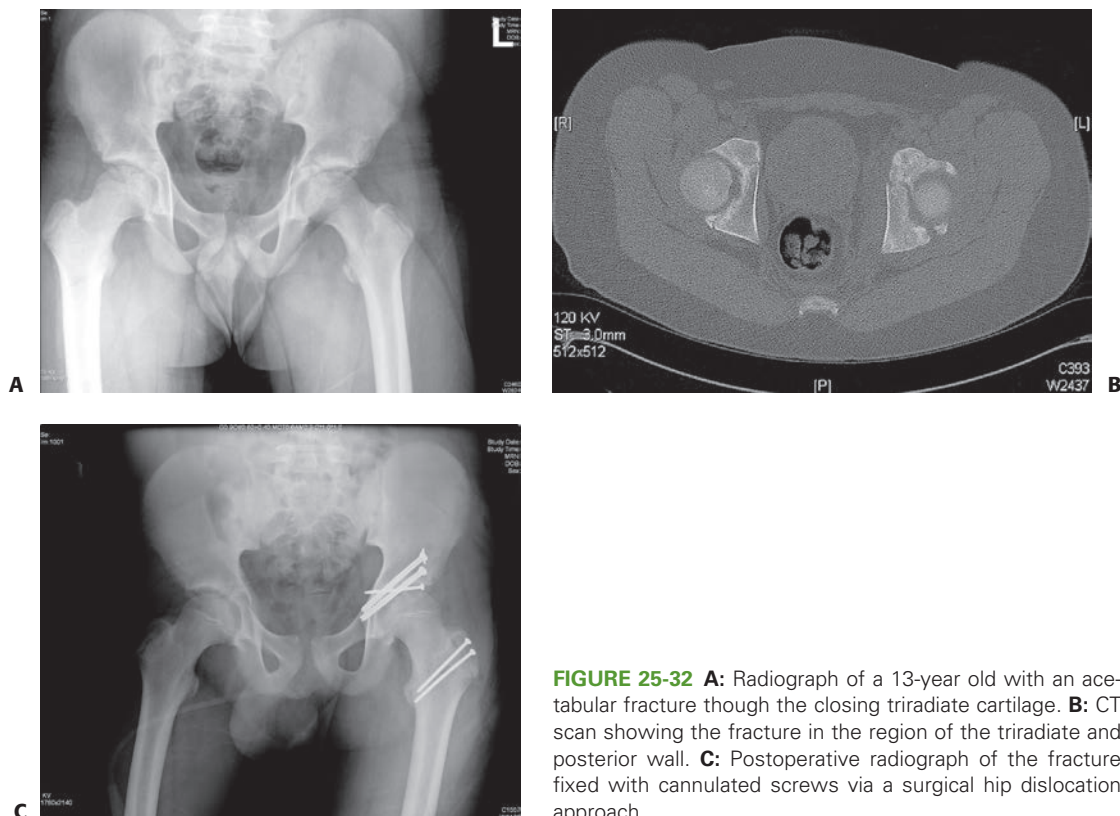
A: Radiograph of a 13-year old with an acetabular fracture through the closing triradiate cartilage. B: CT scan showing the fracture in the region of the triradiate and posterior wall. C: Postoperative radiograph of the fracture fixed with cannulated screws via a surgical hip dislocation approach.
